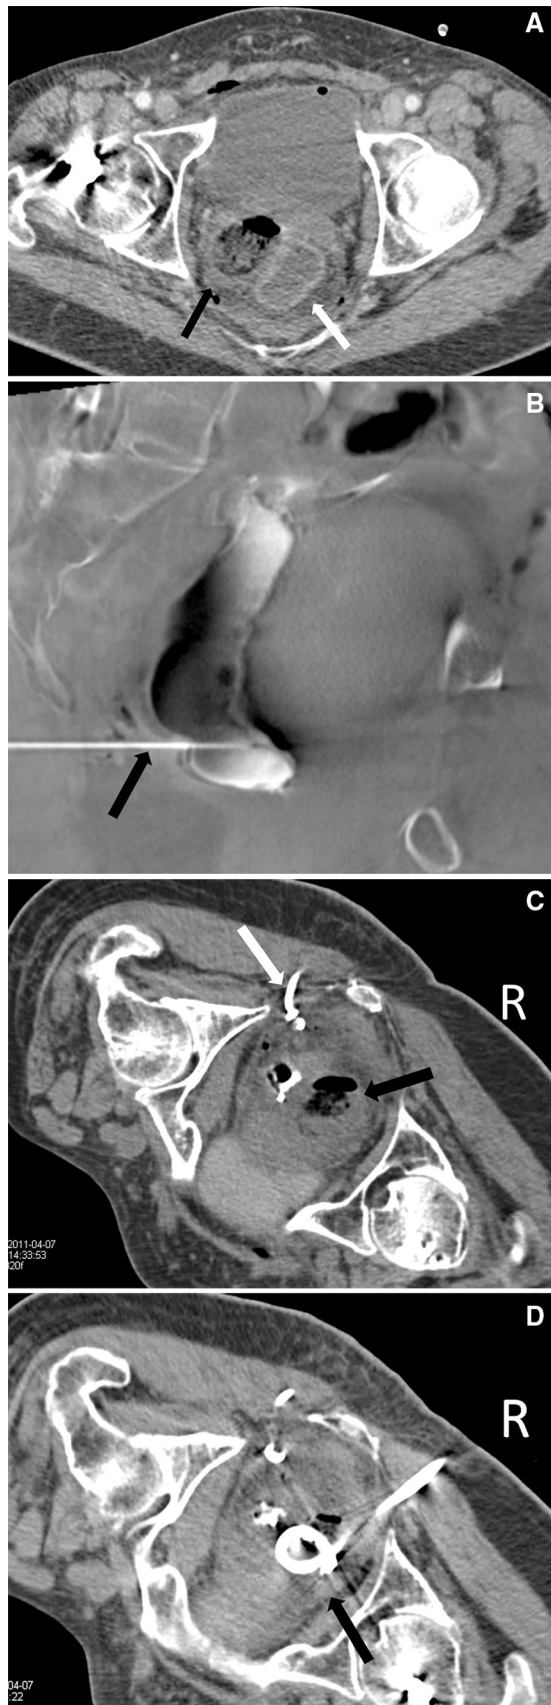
A 63-year-old male with a history of perforated diverticulitis status post left colectomy and diverting colostomy presents with a right perirectal fluid collection. A Contrast-enhanced axial CT image demonstrates an air-filled right perirectal fluid collection (*black arrow*) and fluid-filled rectum (*white arrow*). B Sagittal C-arm flat detector computed tomography image obtained during percutaneous drainage demonstrates an 18-gauge trocar needle (*arrow*) in the contrast-filled rectum. It was decided to leave an 8.5-F Dawson–Muller drainage catheter because the catheter tract was already dilated. C Non contrast-enhanced axial CT image during the CT-guided drainage procedure the following day demonstrates that the previously placed 8.5-F Dawson–Muller catheter is outside the rectum (*white arrow*) and right perirectal fluid collection (*black arrow*). D A 16-French Cope loop catheter (*black arrow*) is successfully placed into the right perirectal fluid collection
